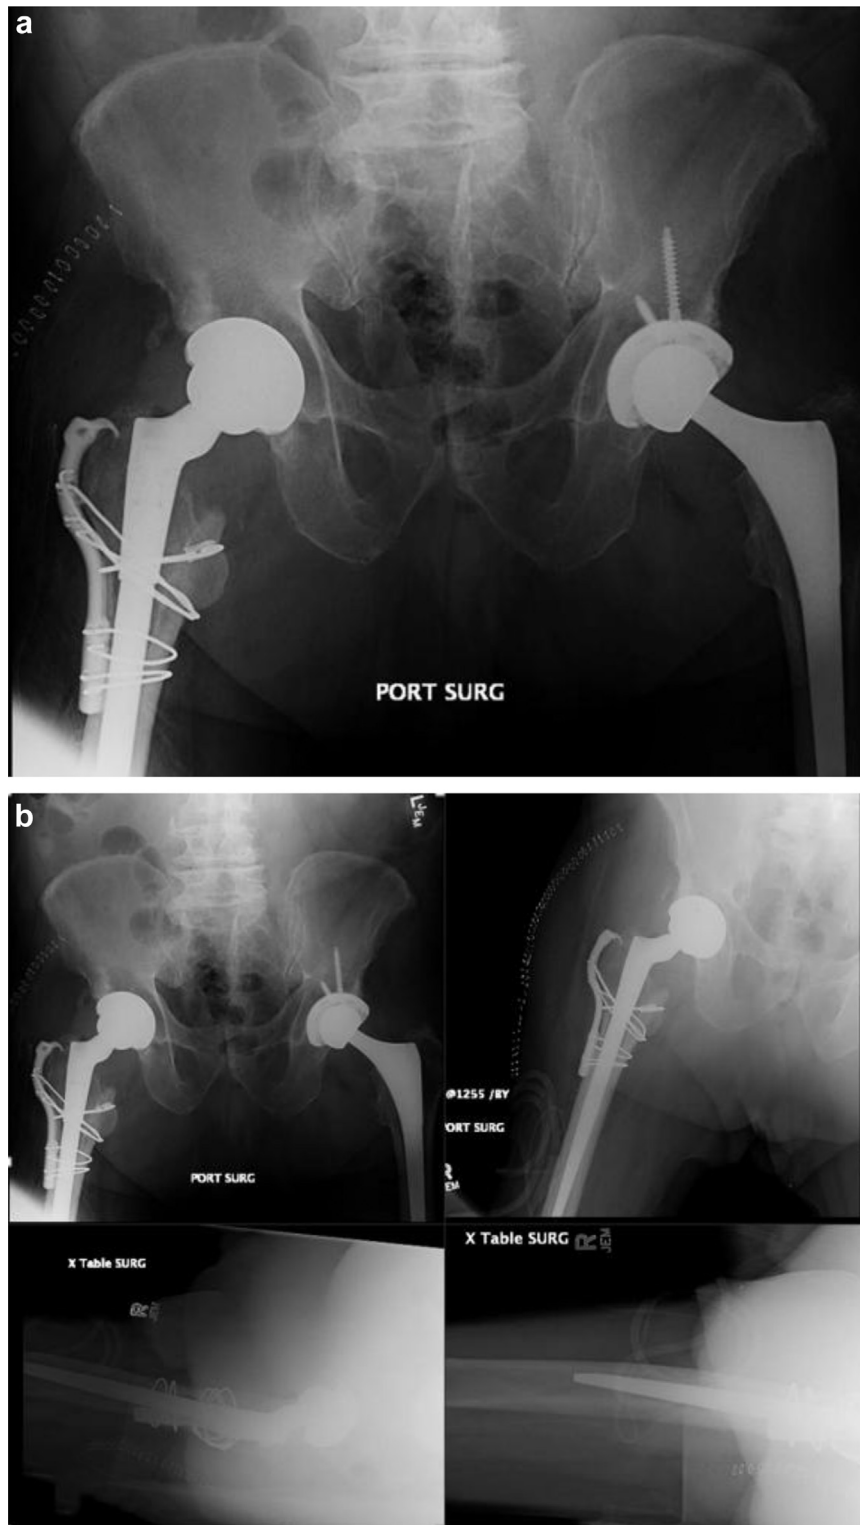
(a) Postoperative anteroposterior pelvis radiograph showing the reconstruction with a modular femoral stem, cables, and greater trochanteric hook plate. (b) Postoperative anteroposterior and lateral radiographs of the right hip from February 2018 after revision right total hip arthroplasty.
